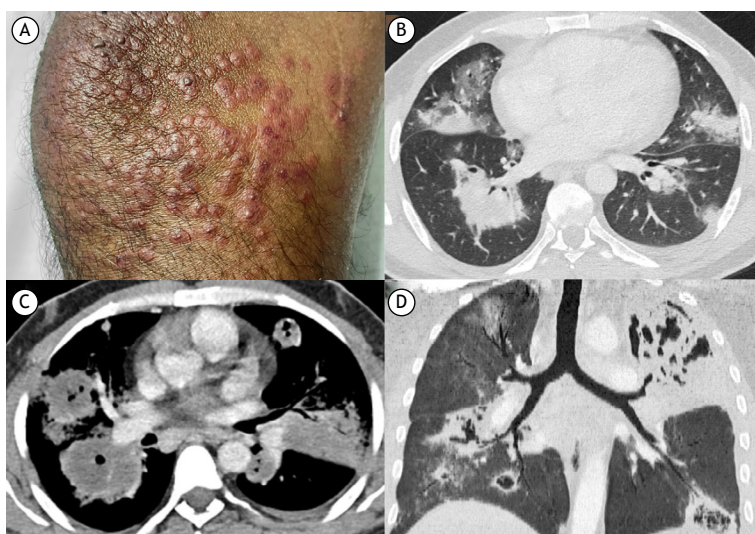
In A, clinical photograph showing palpable purpuric lesions in the lower extremities. In B, non-contrast-enhanced chest CT showing bilateral peribronchovascular consolidations with a surrounding halo of ground-glass opacity. In C, contrast-enhanced chest CT evidenced central cavitation and hypoenhancement within the pulmonary consolidations, suggestive of intralesional necrosis. In D, coronal non-contrast-enhanced chest CT with minimum intensity projection showing progression of the peribronchial lesions, most of which cavitated.
